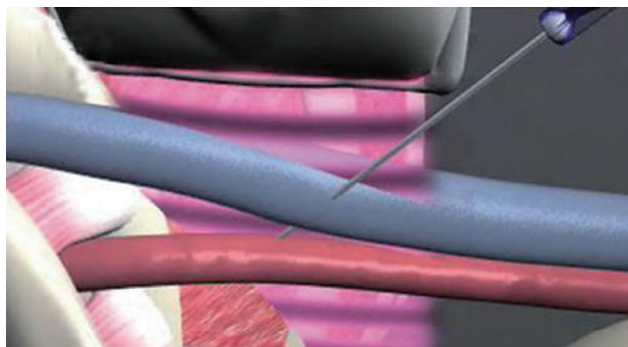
Ultrasound Detecting field
